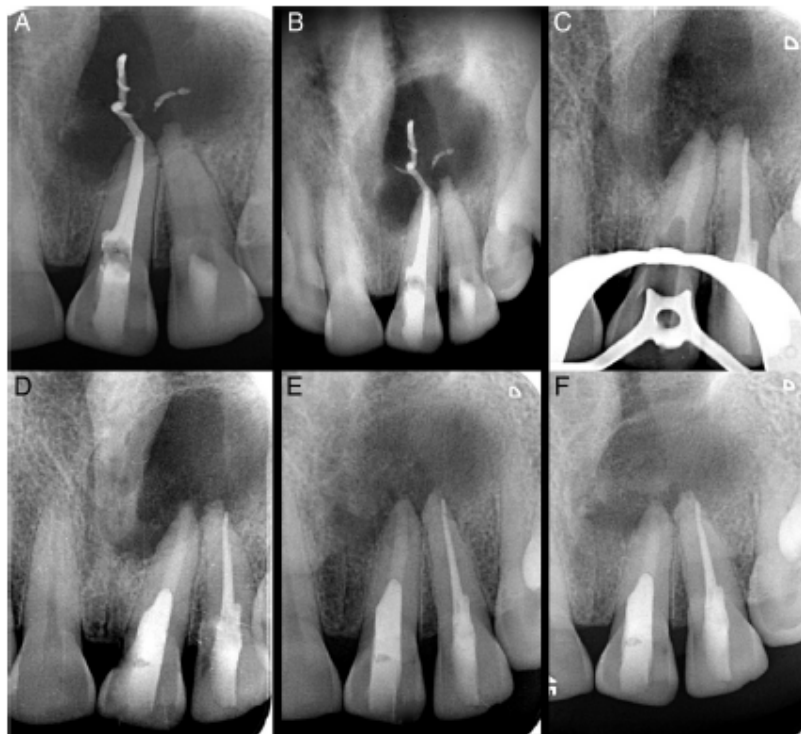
Radiograph images showing the radiolucent area before and after the treatment with Biodentine and PRF
